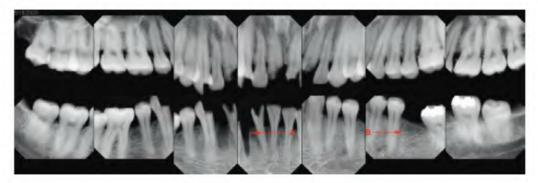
The postmortem full-mouth radiograph series shows missing teeth with an "open" or unhealed tooth socket (a), as well as a "closed" or healed socket (b). The open socket is indicative of a postmortem tooth loss.
